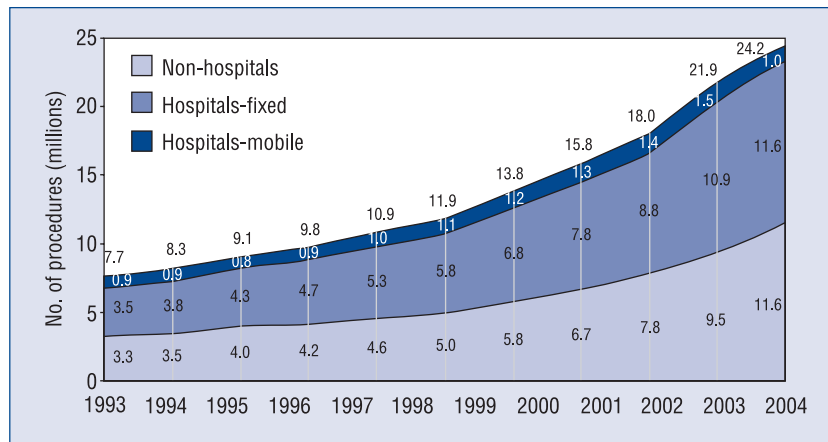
Magnetic resonance imaging (MRI) procedures — total US MRI procedure volume, hospital and non-hospital sites, 1993–2003.
